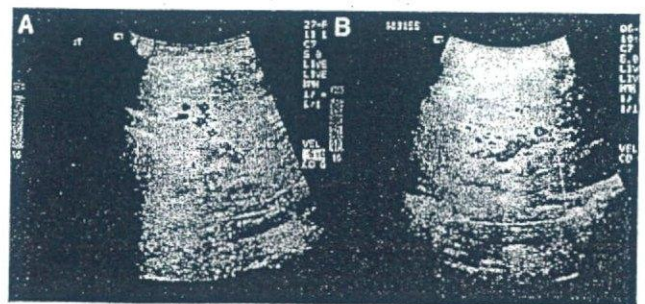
Doppler ultrasonography study before (A) and after (B) the systemic thrombolytic therapy in case 3. Before the treatment, no portal flow was detected at umbilical portion of the graft, whereas it reversed with flow velocity of 10 cm/sec after the therapy.
